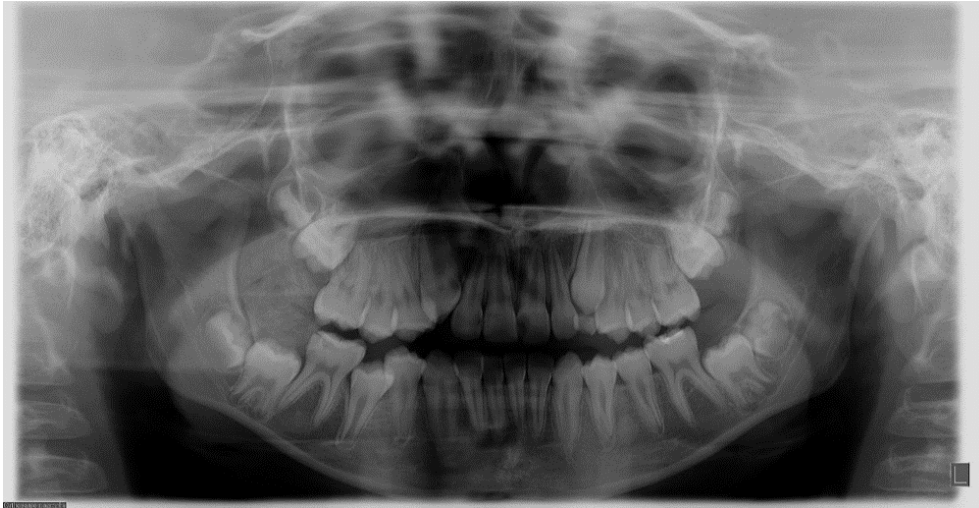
Panoramic radiography showing radiopaque lesion on the posterior right side of the mandible, superiorly to the lower second molar.
